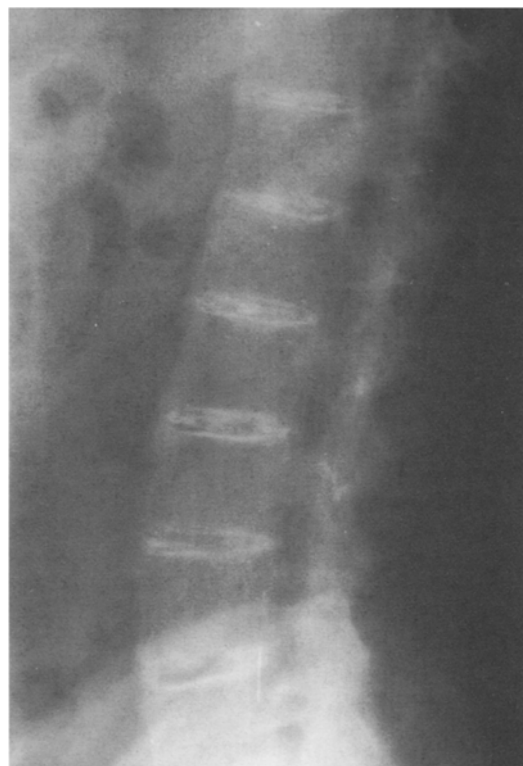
A lateral radiograph of the lumbar spine showing typical wafer-like calcifications in the intervertebral discs.
